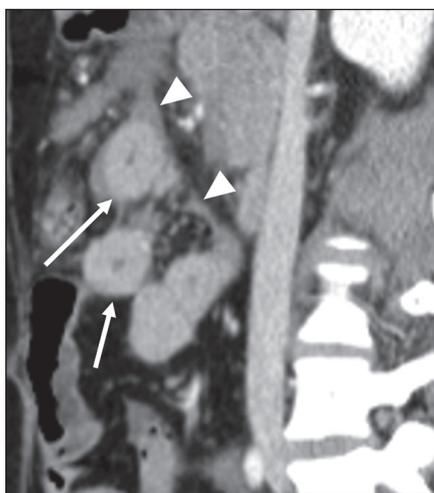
Mesenteric fluid secondary to bowel injury. Sagittal reformation of CT examination obtained in patient who was involved in car accident shows thickened loops of small bowel (*arrows*) with associated triangular pockets of high-attenuation fluid located between leaves of small bowel mesentery (*arrowheads*). At laparotomy, multiple segments of bowel with contusion and ischemia were found.
